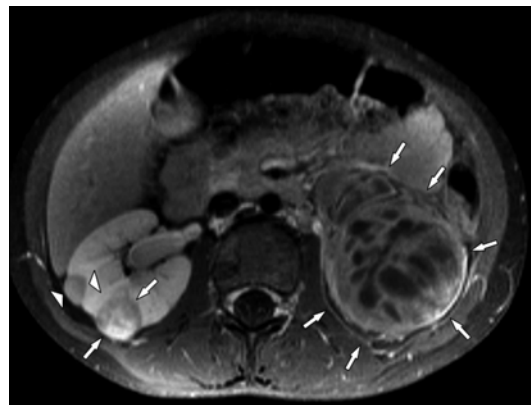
A 4-year-old boy with bilateral Wilms' tumor and nephroblastomatosis. Transversal fat-suppressed T1-weighted image after contrast enhancement reveals bilateral nephroblastoma (arrows) and a right-sided nephroblastomatosis lesion (arrowheads). Exact detection of bilateral nephroblastoma and nephroblastomatosis lesions is essential for further surgical planning
